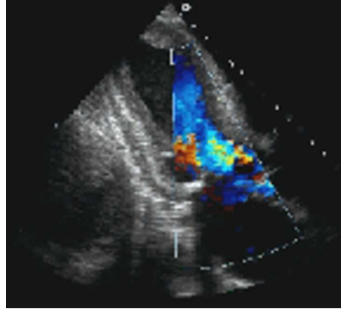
B-mode ultrasound slice with superimposed colour Doppler showing blood flow inside the heart (from AnaesthesiaUK)
